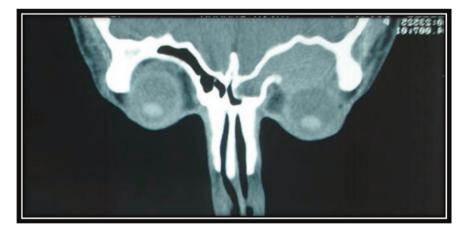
CT-scan, shows mucocele within the frontal sinus leading to inferior displacement of the left globe
